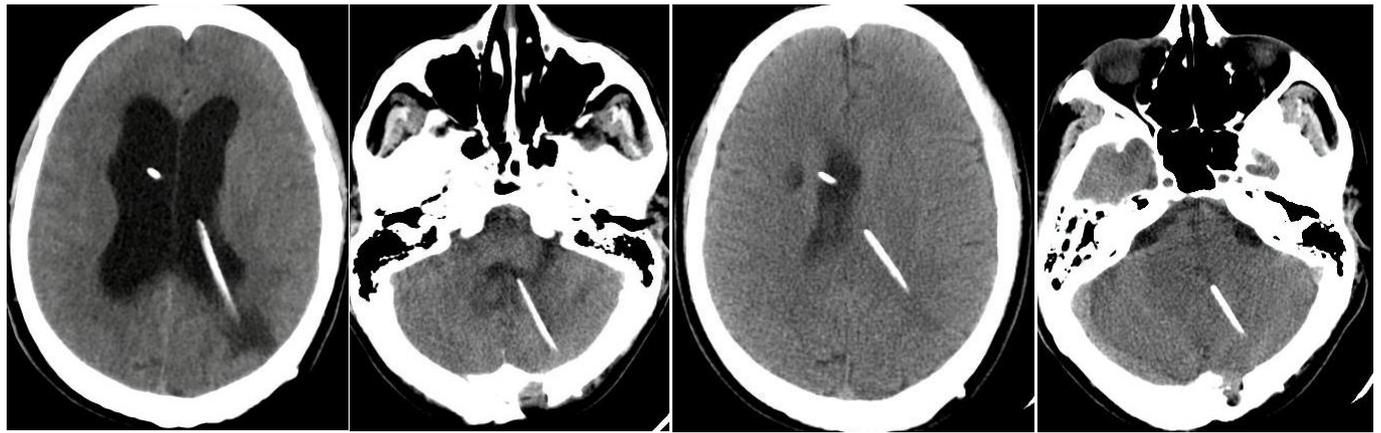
(A and B) Computed axial tomography (CT) of the brain ventricle in the immediate postoperative period after the last VPS surgery, in axial section at the level of lateral ventricles and the fourth ventricle that still shows ventricular dilation, with the right frontal ventricular catheter buried and functioning parietooccipital and left posterior fossa ventricular catheters. (C and D) Cerebral CT scan in axial section at the level of lateral ventricles and the fourth ventricle (1 month after the last one) that shows ventricular collapse, with the right frontal ventricular catheter buried, the parietooccipital ventricular catheter and left posterior fossa.
